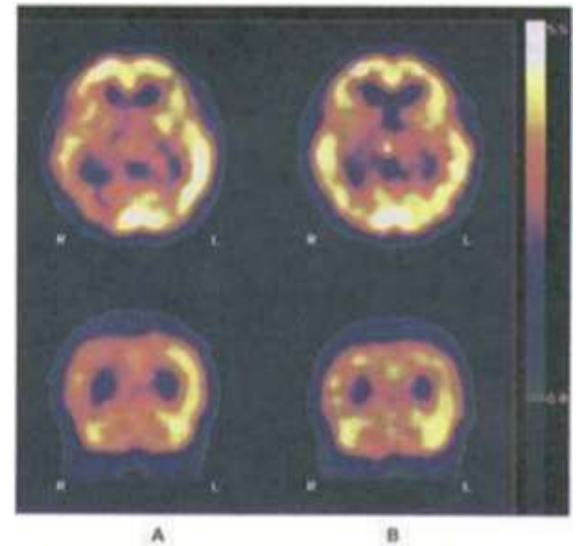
Single photon emission computed tomography demonstrating relative hypoperfusion in the right parietal and occipital regions in the aura period (A). Normal findings a week later (B).
